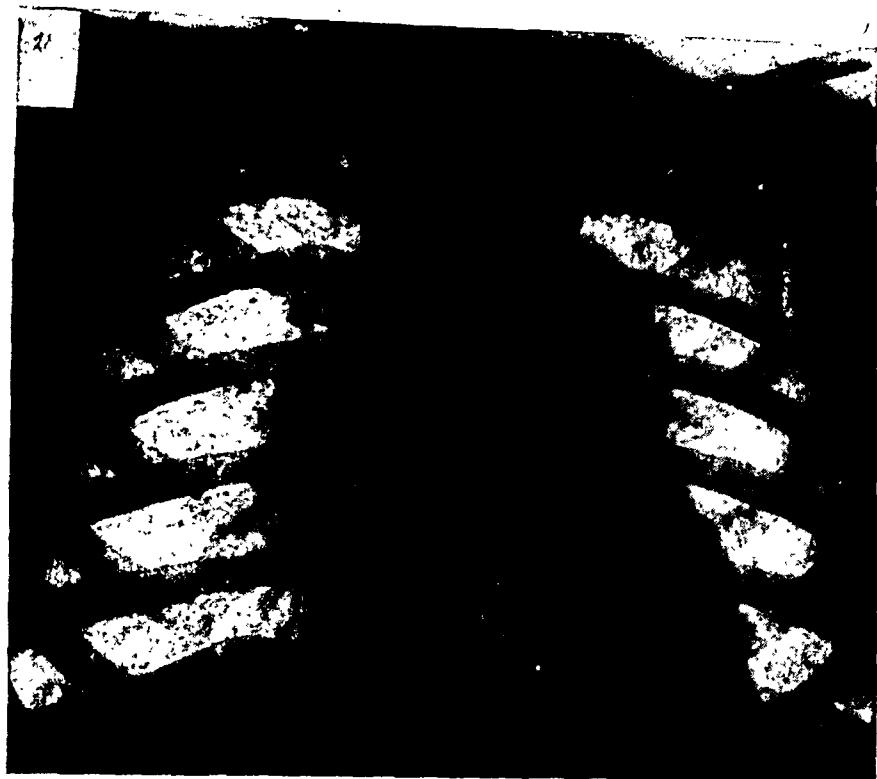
Radiograph of the lungs in case 2 on admission: diffuse coarse mottling of both lungs with broadened hilar shadows.
